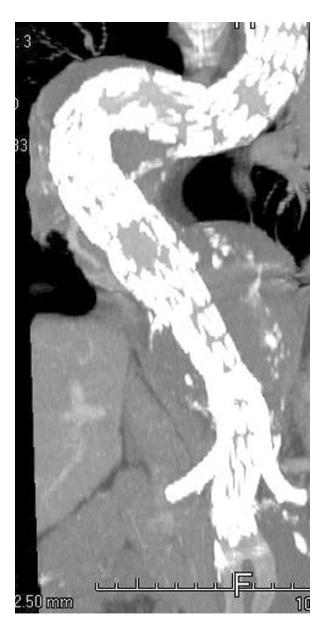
A postoperative computed tomography scan shows a tortuous stent graft within a tortuous aorta.
